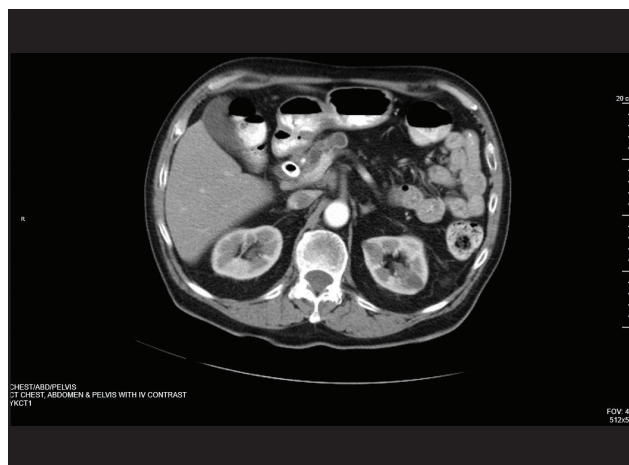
CT image of pancreatic mass after third RFA treatment
